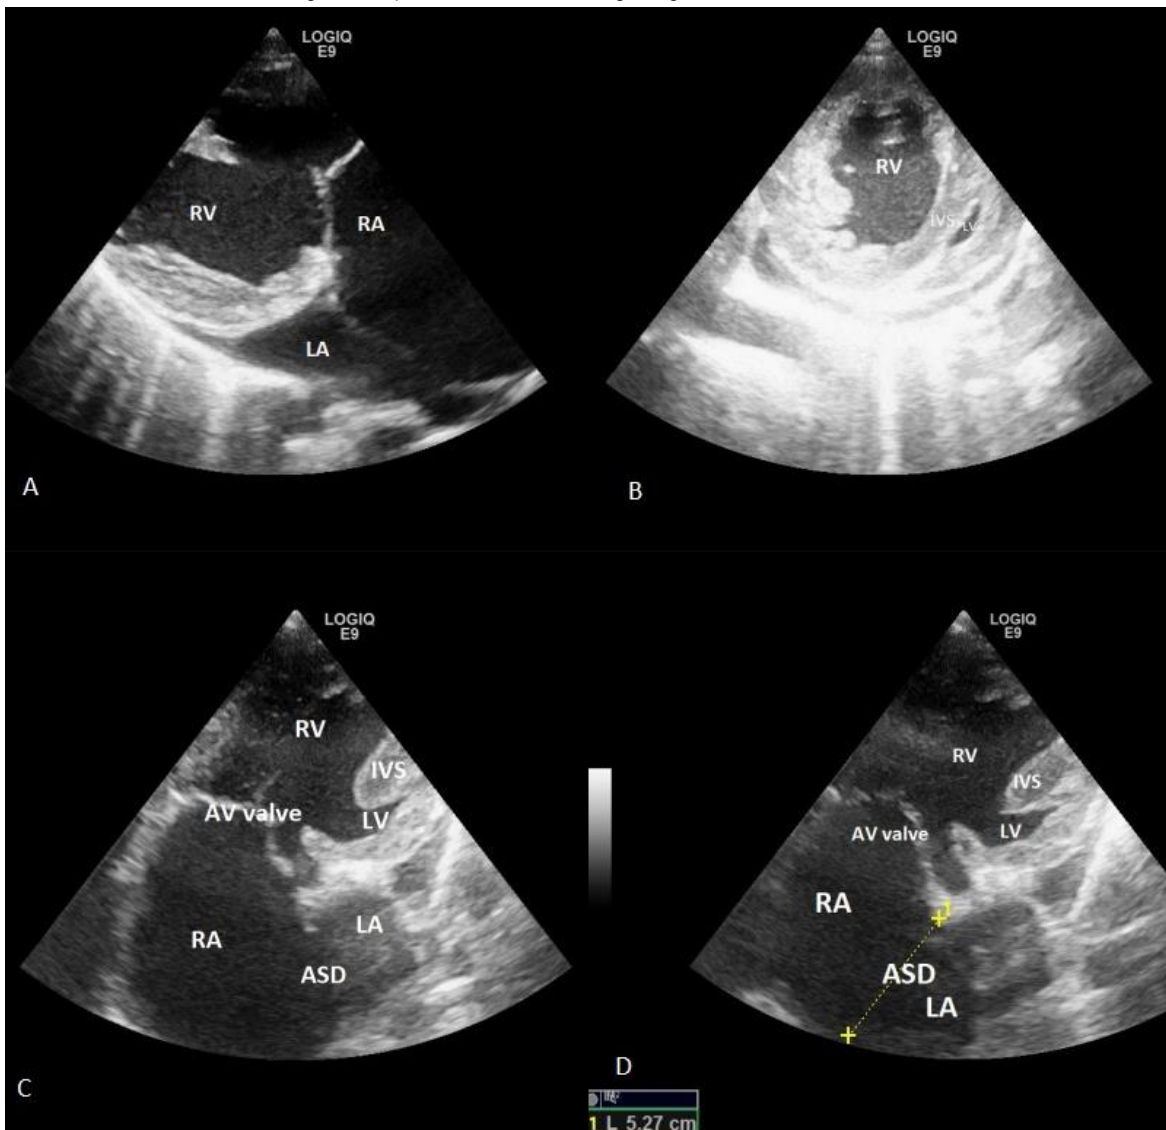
Echocardiography.
